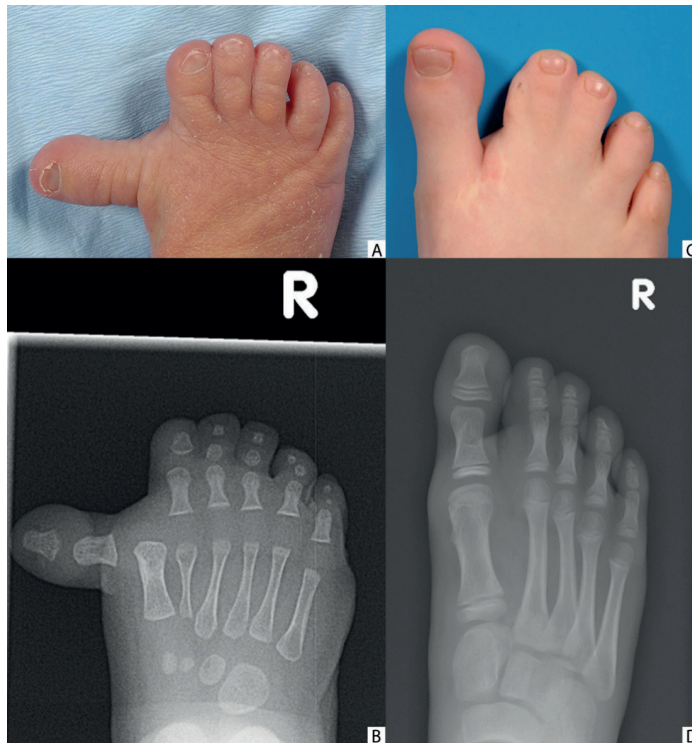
(A) Preoperative clinical photograph. (B) Preoperative radiograph x-ray. (C) Postoperative clinical photograph. (D) Postoperative x-ray.
